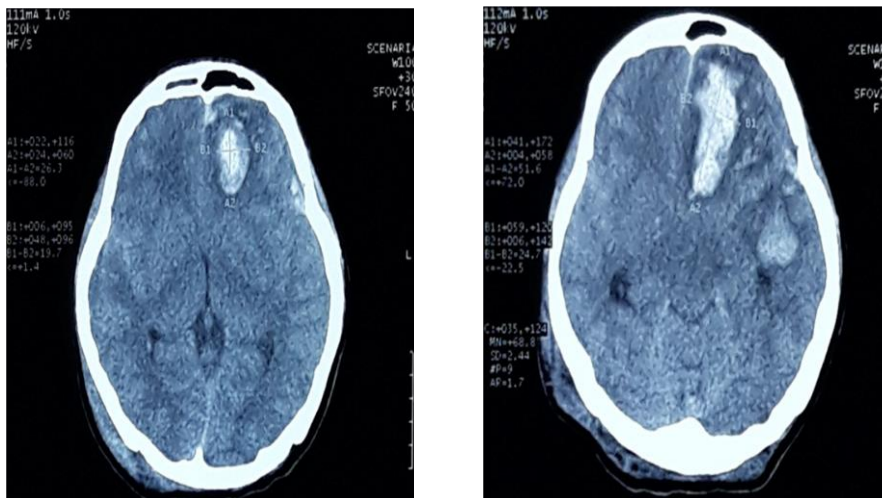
an axial pre-operative CT scan show multiple contusions at left-right frontal region and enlargement of intracerebral hemorrhage (ICH) at left frontal region, causing midline shift > 0,5 cm to the contralateral side)
